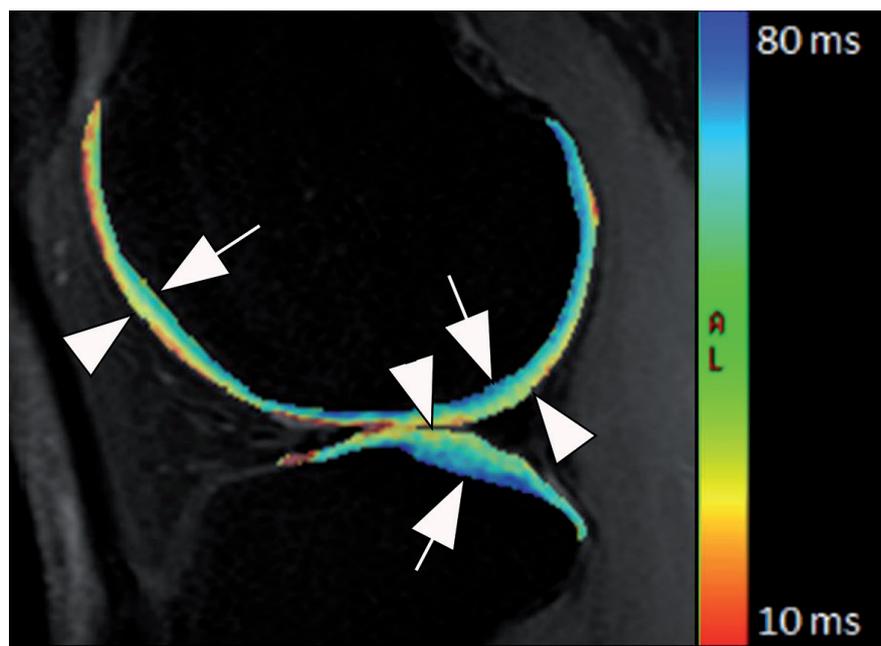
Compositional MRI. Sagittal multi echo spin echo (MESE) image of the lateral compartment shows T2 values of the articular hyaline cartilage in colour-coded fashion. Note differences in superficial vs. deep cartilage layers with deep layers showing higher T2 values (arrows) compared to superficial layers (arrowheads).
